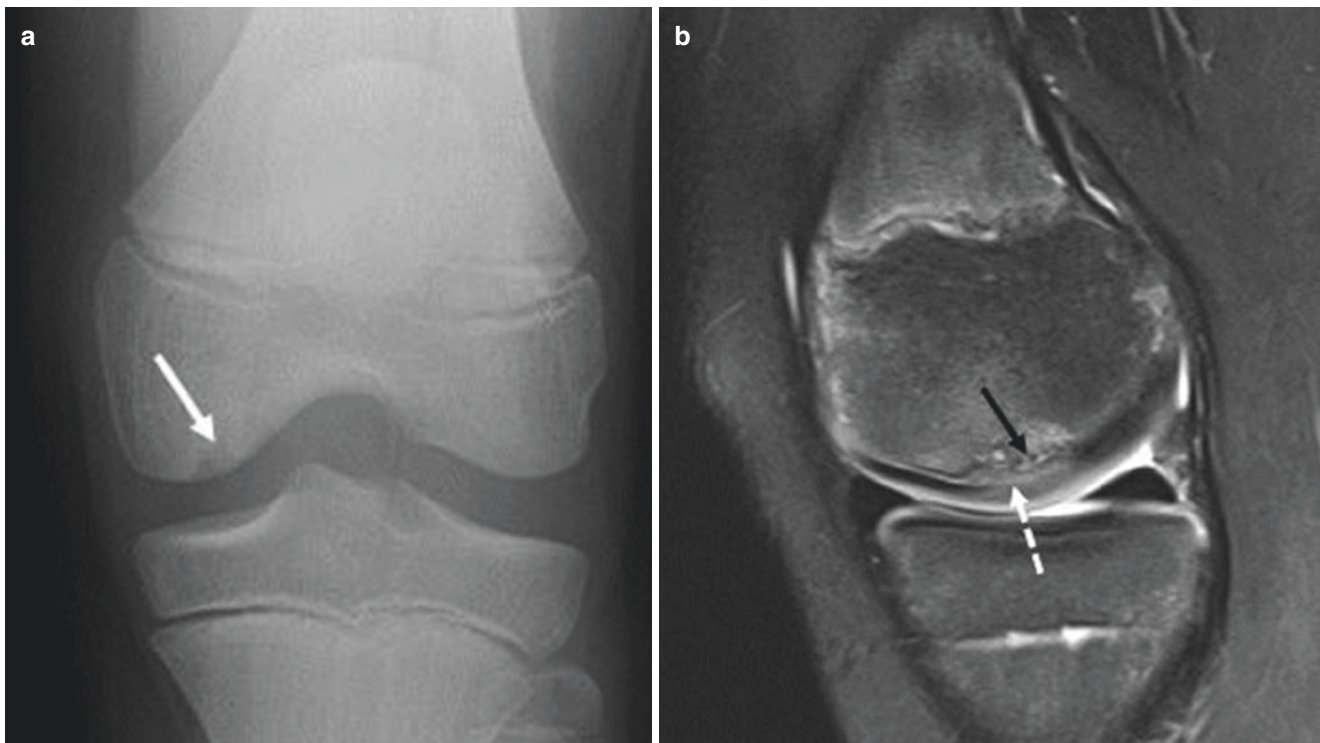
(a, b) Osteochondritis dissecans in a 10-year-old male soccer player with knee pain. The frontal radiograph (a) shows subchondral lucent lesion with marginal sclerosis involving the weight-bearing, intercondylar notch region of the medial femoral condyle (white arrow). The sagittal T2-weighted image with fat suppression (b) shows
